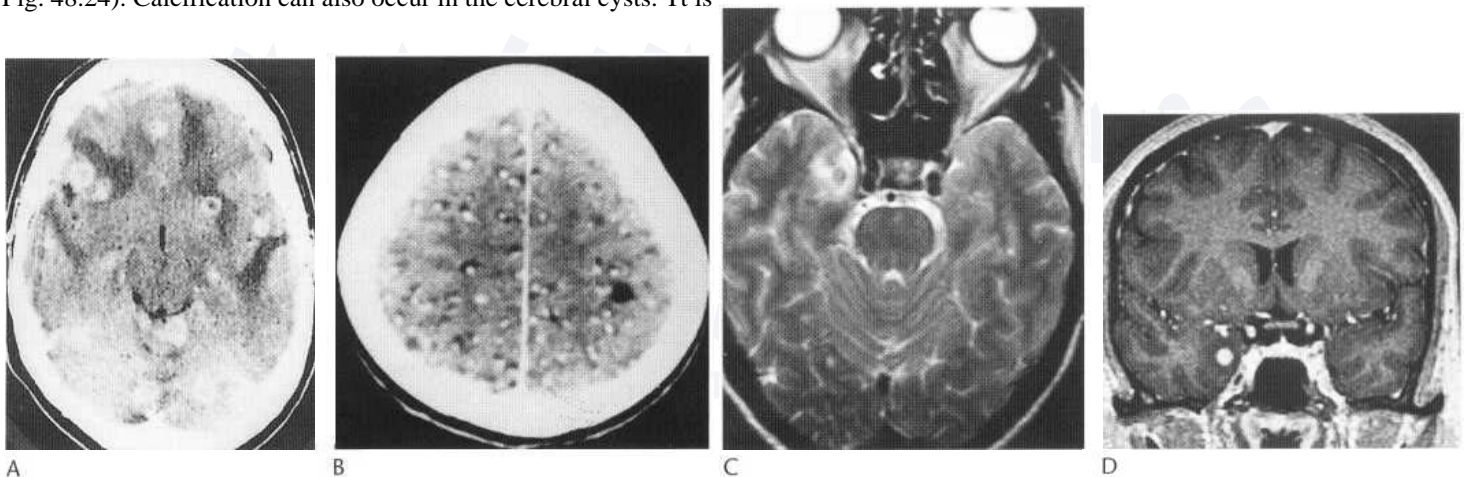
Enhanced CT in acute cysticercosis. (A) Multiple ring and nodular lesions inconstantly accompanied by oedema. (B) Another patient with chronic quiescent cysticercosis. The brain was riddled with cysts and calcified nodules. (C) The axial T₂-weighted MR in this patient who presented acutely with epileptic seizures showed a small hypointense lesion in the medial right temporal lobe associated with a small amount of vasogenic oedema. (D) On the postcontrast T₁ coronal image, this lesion showed almost uniform enhancement and resolved on treatment for cysticercosis.
